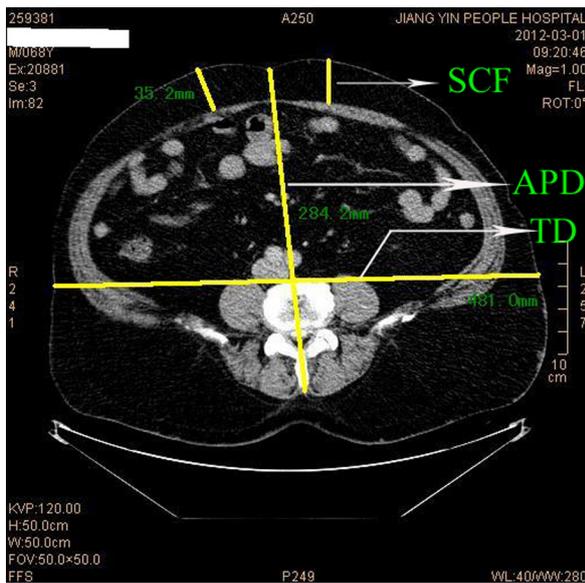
CT scan measurement indexes: SCF (subcutaneous fat), that is the thickness of subcutaneous fat, which is the maximum value from dermis down to rectus abdominis anterior sheath; APD (abdominal anterior-posterior diameter), that is abdominal anterior-posterior diameter, which is the measuring distance between the line from umbilicus to spinous process and abdominal wall section and lumbar section; TD (abdominal transverse diameter), that is abdominal transverse diameter, which is the measuring distance of front horizontal line of lumbar vertebra.
